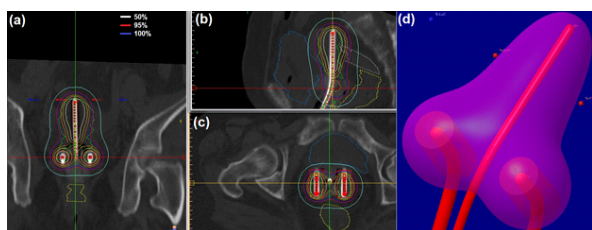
Dose distribution on CT images in (a) frontal, (b) sagittal, (c) transversal view and (d) 3D dose reconstruction in pear shape
